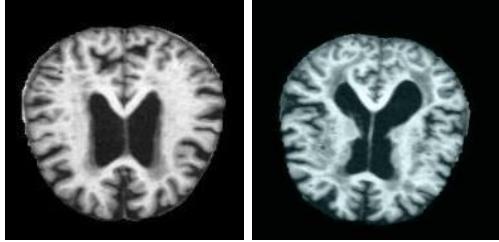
MRI Scan of Skull
